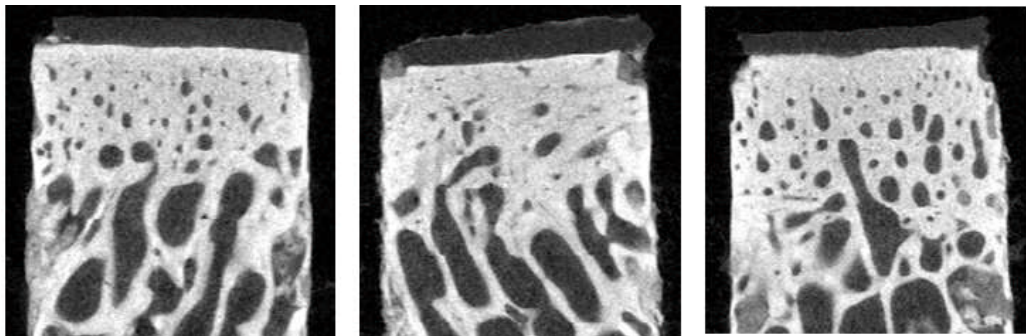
Examples of μ CT scan image of cartilage pins at middle slice.
